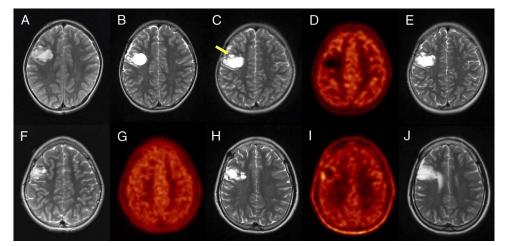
The clinical activity of DNETs may change and MET uptake correlates with the phase of the tumor. The first patient, a 6-year-old boy, with a right central lobe DNET (A) had STR of the tumor, which was confirmed on postoperative MRI (B). Follow-up MRI at 2.2 years after surgery demonstrated progression of the residual tumor with increased extent of the high signal intensity lesion on T2-weighted MR images (arrow) (C). MET-PET was performed for further evaluation, and tumor uptake was low (D). On the 4.9 years follow-up MRI, there was no evidence of tumor progression (E). The second patient, a 10-year-old girl, was diagnosed with a right central lobe DNET on MRI (F), and initial MET-PET showed moderate tumor uptake (G). After NTR of the tumor, seizure recurred at postoperative 3.5 years. Follow-up MRI (H) and MET-PET (I) images obtained after seizure occurrence revealed a progressed tumor with high MET uptake in a rim-like pattern. The patient underwent reoperation and NTR of the tumor was performed, but the 6.3 years follow-up MRI after reoperation showed tumor progression (J).
